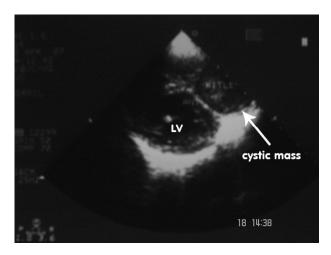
Transthoracic two-dimensional echocardiogram of parasternal long-axis view showing a hydatid cyst (arrow).
